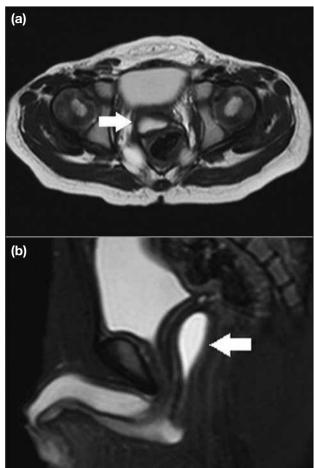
Posterior urethral diverticulum. This male patient presented with an intermediate-type anorectal malformation at age 6 months and underwent laparoscopically assisted anorectoplasty as the second surgical repair. At age 2 years, magnetic resonance imaging was performed for evaluation of a cystic lesion anterior to the rectum, which was asymptomatic and incidentally detected using ultrasonography. Surgical resection was performed. (a) Axial T2-weighted image showing cystic lesion with high signal intensity between the rectum and bladder (arrow). (b) Sagittal fat-suppression T2-weighted image showing the oval lesion posterior to the urethra (arrow).
